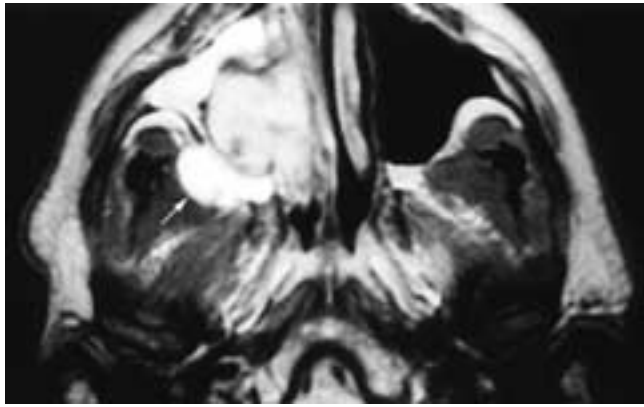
Axial T2-weighted MR image shows the tumor to have a high signal intensity, but not as high as the signal intensity of the obstructed secretions in the right antrum. The chronic antral obstruction has led to the development of a mucocoele (arrow), which bulges into the right infratemporal fossa. This patient had a hemangioma.
